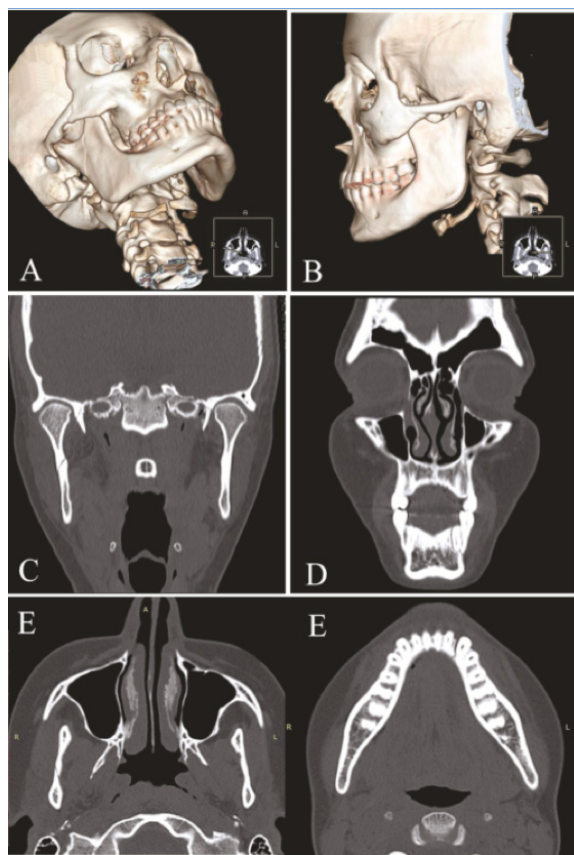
CT scan images showing the high mandibular ramus fracture on the right side and the parasymphysis fracture on the left side
